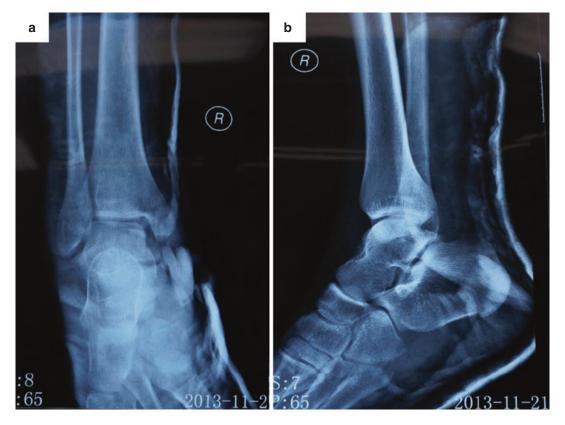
(a) AP, (b) Lateral radiographs of the right ankle after closed reduction
